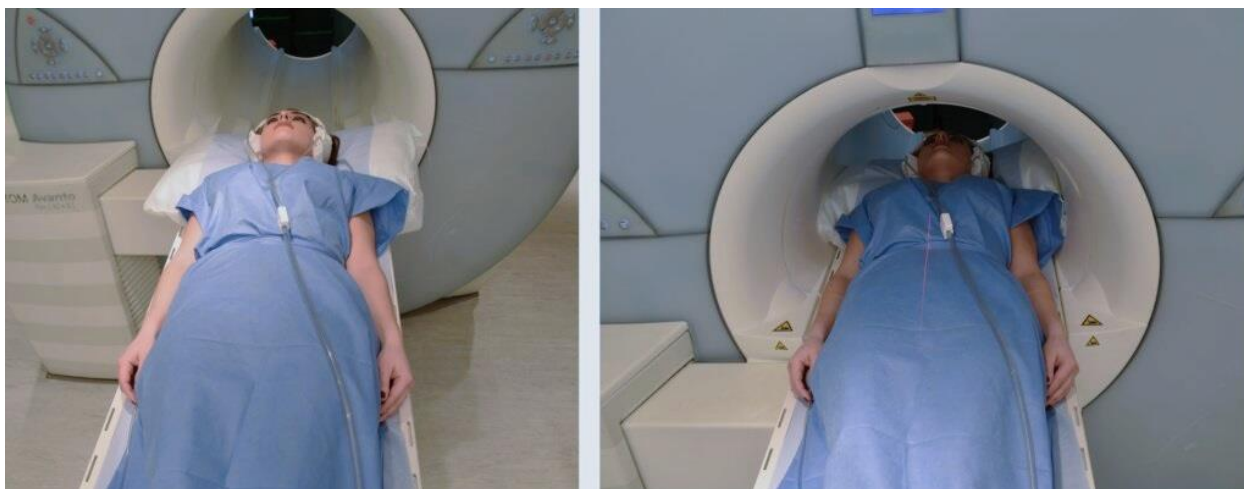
A Patient under MRI examination
